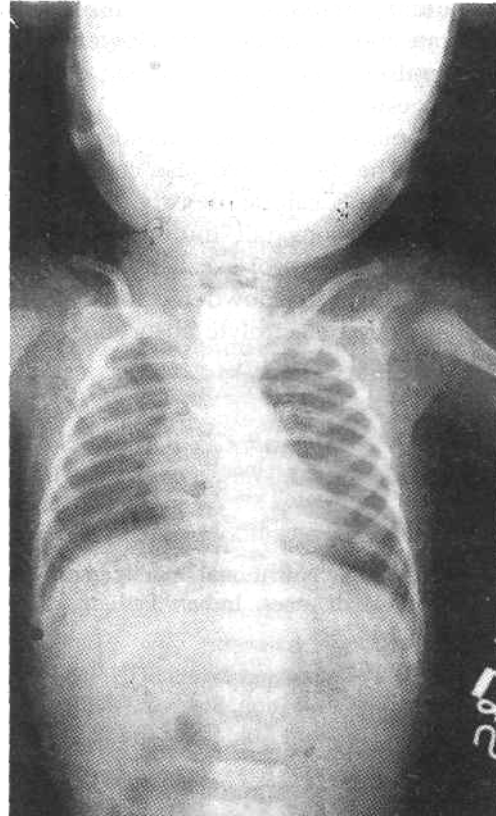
X-ray Chest AP view showing dense opaque foreign body in the neck.
